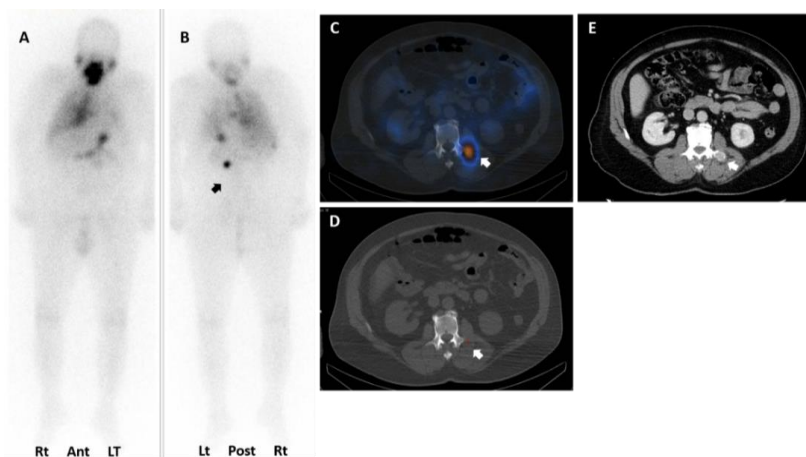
Case 2: 65 years old male with papillary thyroid carcinoma post total thyroidectomy. Apart from iodine avid residual thyroid tissue and right lung uptake noted on whole body images (A & B), a focal uptake is seen in abdominal left paramedian region (black arrow). SPECT/CT imaging (C, D & E) revealed a metastatic osseous lesion in left transverse process of L2 vertebra (white arrow).
